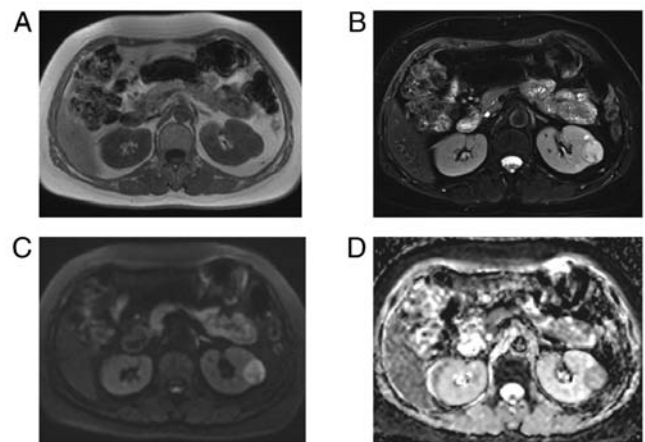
Magnetic resonance imaging findings. (A) An intense circumscribed round mass signal was detected in the left kidney on T1WI. (B) The mass was hyperintense with a small hypointense area on T2WI. (C) DWI ($b=800 \text{ sec/mm}^2$) presented a high signal. (D) ADC presented a low signal ($\text{ADC}=1.47 \cdot 10^{-3} \text{ mm}^2/\text{sec}$). T1WI, T1-weighted imaging; T2WI, T2-weighted imaging; DWI, Diffusion weighted imaging; ADC, apparent diffusion coefficient.
